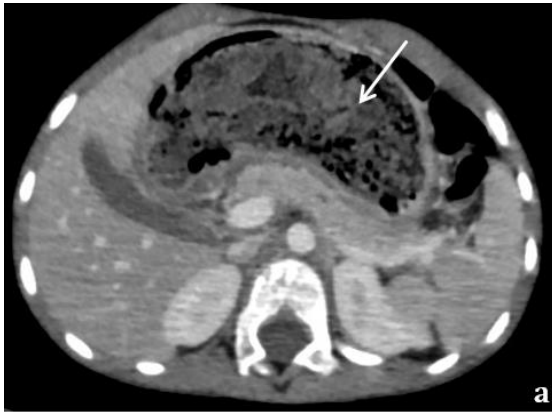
Abdominal CT on axial reconstructions showing gastric trichobezoar (a) extending into the duodenum and jejunum (b) (arrows)
